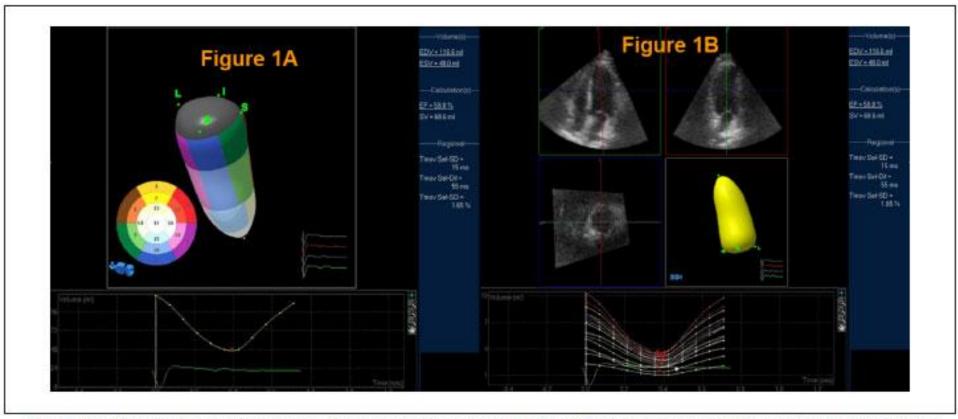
Three-dimensional echocardiographic image of the left ventricle (17-segment model, Figure 1A), with measurements of ventricular ejection fraction and volumes. Volume and ejection fraction measurements were derived from the two-dimensional echocardiography (Figure 1B) as analyzed in multiple observation planes.
